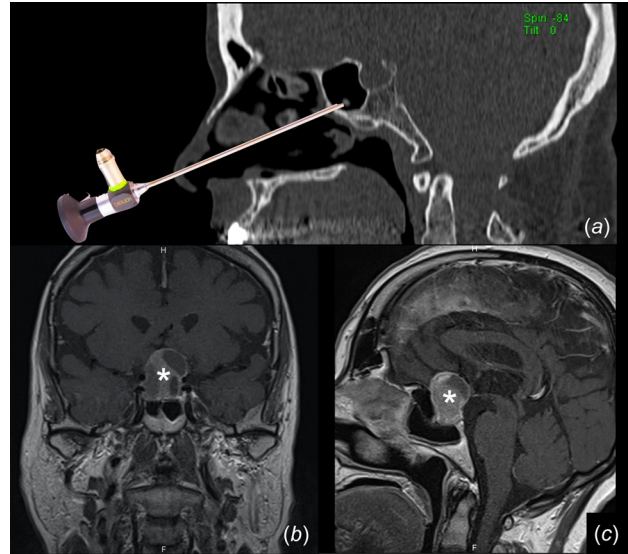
Magnetic resonance imaging and computed tomography (CT) scans of a patient with pituitary tumor. Depiction of endoscope and surgical field in midsagittal plane is given (a). A macroadenoma (asterisk) can be seen in coronal (b) and sagittal (c) magnetic resonance images.
